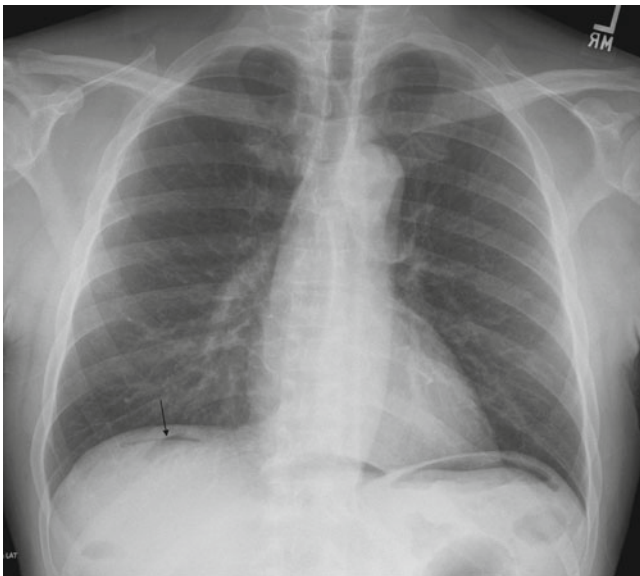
A 73-year-old man presents with acute abdominal pain. Erect, upright PA (frontal) chest X-ray shows air (black arrow) under the diaphragms indicating free air in the peritoneal cavity, usually from a perforated viscus. Diagnosis: Perforated viscus
